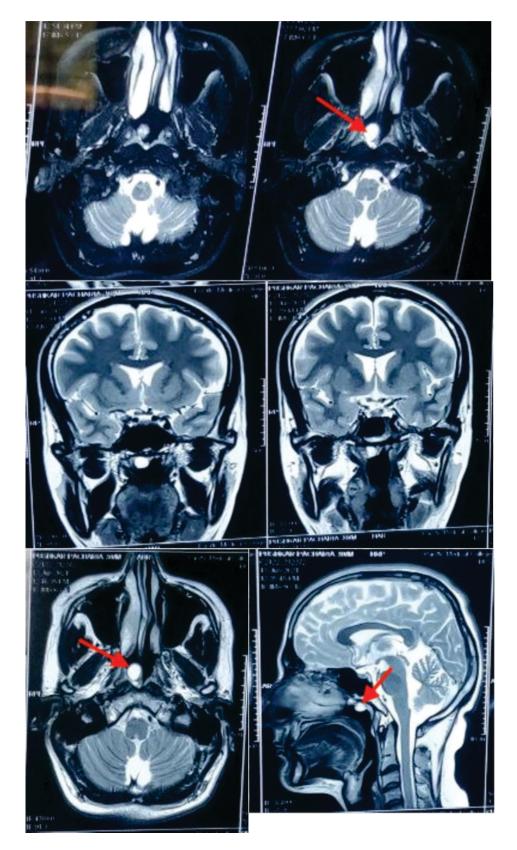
MRI showing mild enhancement mass in nasopharynx region marked with red
